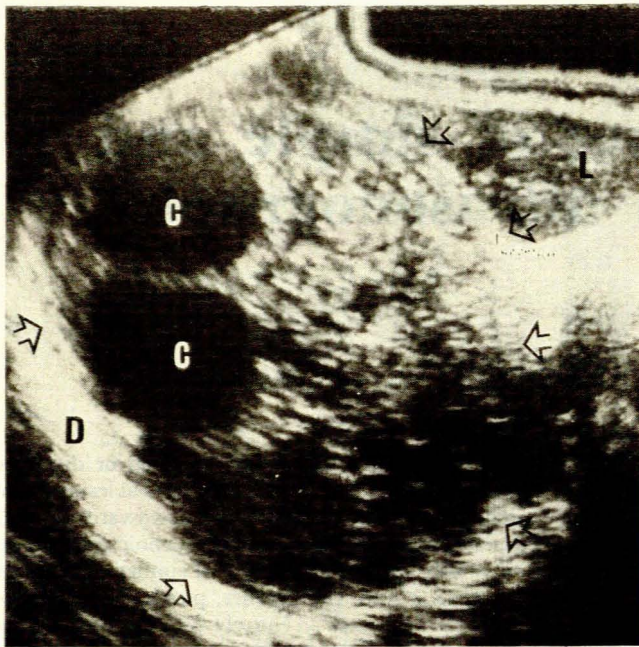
Case 2. Longitudinal ultrasonogram through right lobe of liver (L) revealing a large pseudosolid echinococcal cyst with well-defined rim (arrows) and containing daughter cysts (Cs) (D — diaphragm).
